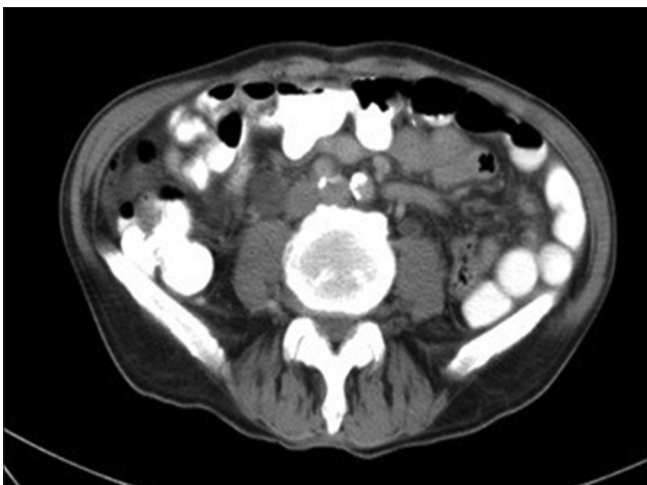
The abdominal computed tomography revealed multiple gas-filled cysts in the wall of the ascending and transverse colon and also in the small intestine
